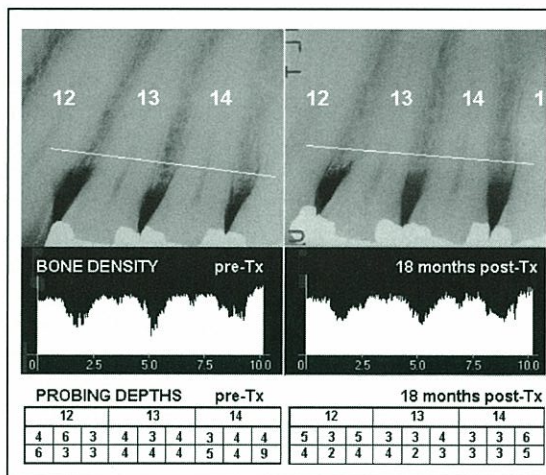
Case 4. Top: Radiograph showing close-up of teeth Nos. 12, 13, and 14 before treatment (left) and 18-month post-treatment. Teeth were aligned and gray scales balanced using Emago software. The straight line drawn across the images indicates the location of the radiographic density profiles. Middle: Density profiles of line drawn on images. Bottom: Probing depths for teeth Nos. 12, 13, and 14 prior to treatment and at the 18-month follow-up exam.
